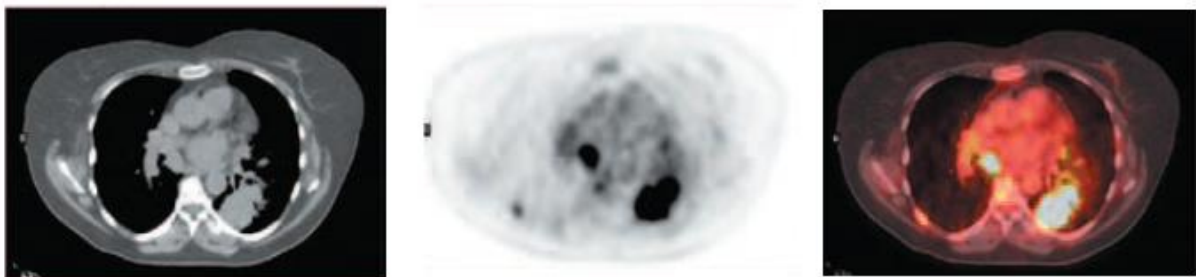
The CT scan is acquired first, followed by the positron emission tomography (PET) scan (without attenuation correction). The CT is then used for attenuation correction of the PET scan. The PET and CT scans are fused by overlaying the PET image, converted with a colour scale, onto the CT (1).
